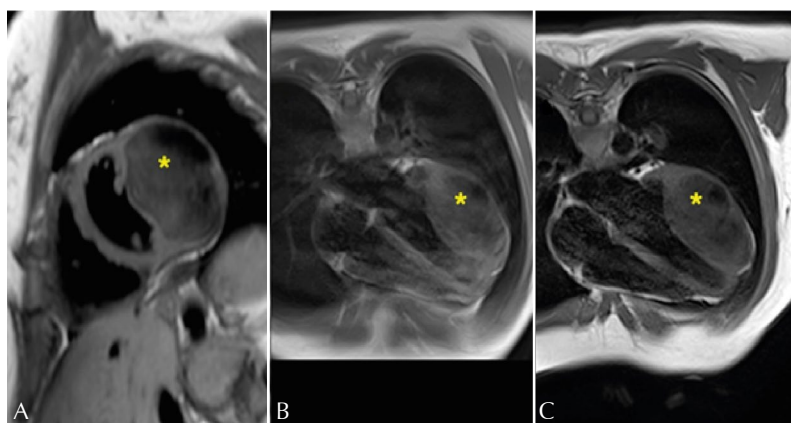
Short-axis (A) and four-chamber (B-C) section showing intramyocardial mass (*) isointensity on T1-weighted cardiac magnetic resonance. Follow-up images from 2016 (A), 2018 (B), and 2020 (C).
